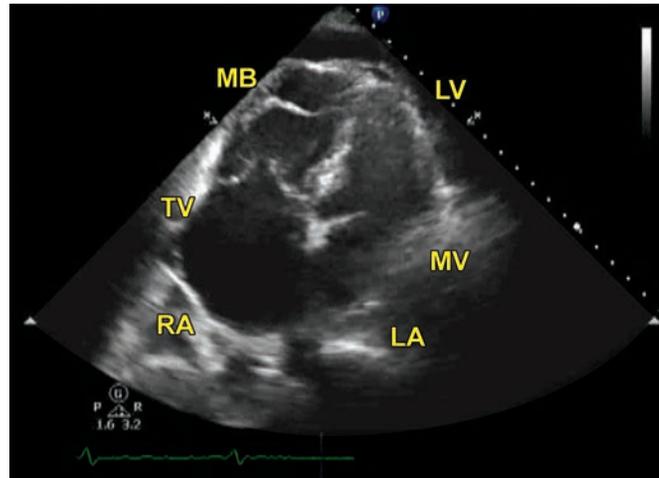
TTE. Apical four chamber view showed complete disappearance of the thrombus.
